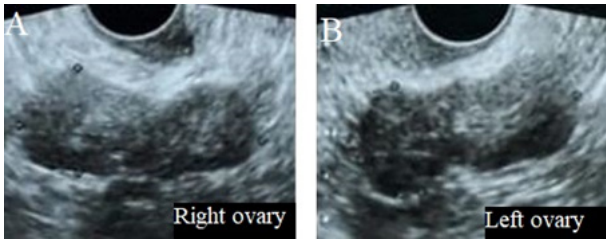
Ultrasonography demonstrating a lobulated and heterogeneous mass in the right ovary (A) and in the left ovary (B).
